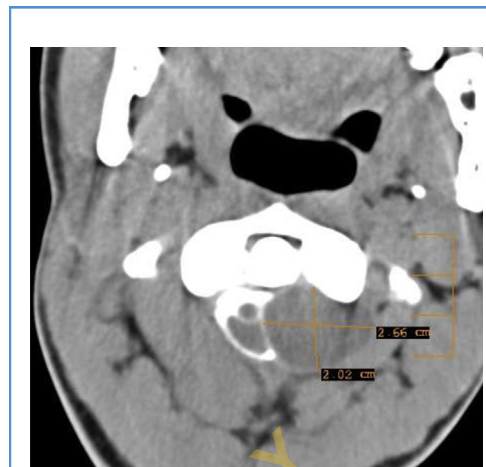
Computed tomography myelography image showing left extradural schwannoma at the level the atlas. The patient underwent hemiresection of the posterior arch of the atlas and gross total excision of the lesion.
